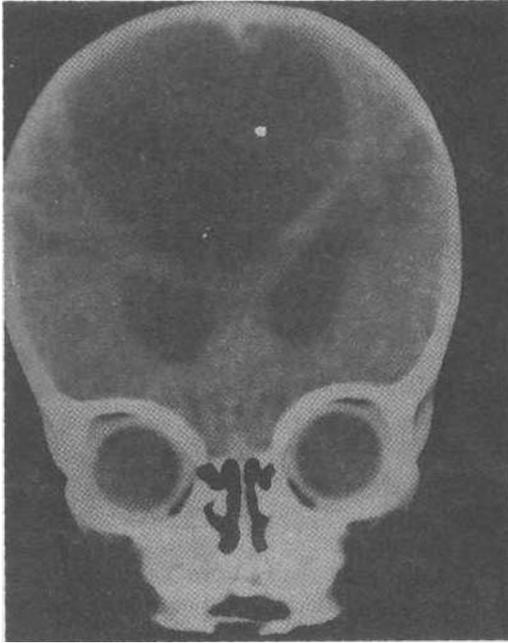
Computed tomography of the brain showing large midline interhemispheric cyst with displacement of lateral ventricles.
